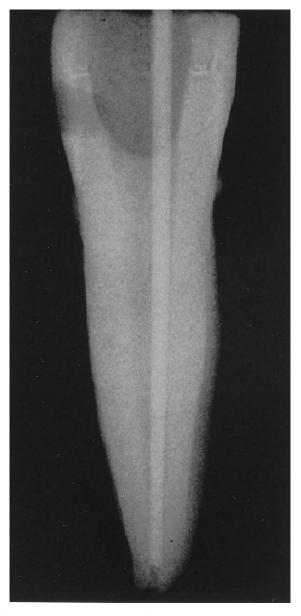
Radiograph confirming the length of the master cone (MicroSeal, SybronEndo).
